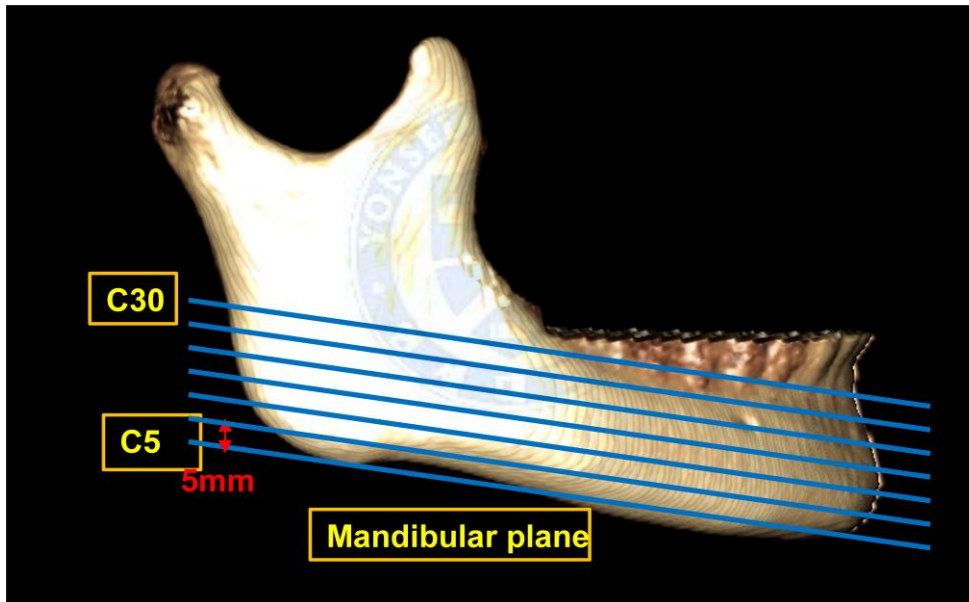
CBCT image cut level- C5, C10, C15, C20, C25, C30; mandibular CBCT image were cut by 5 mm thickness parallel to mandibular plane.
